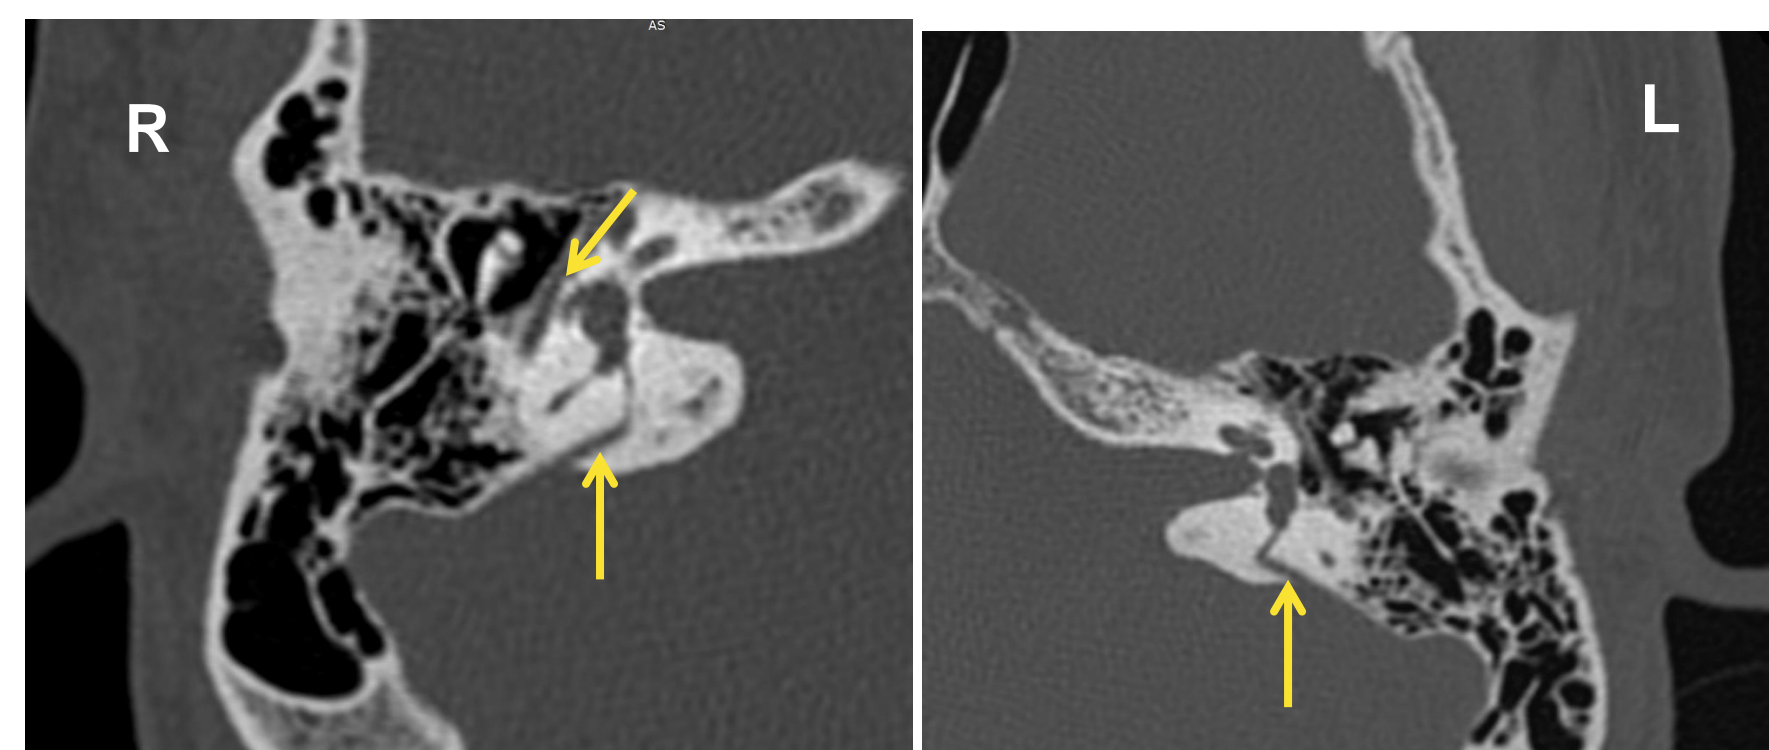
Axial CT scan showing bilateral translabyrinthine fracture (yellow arrow)
